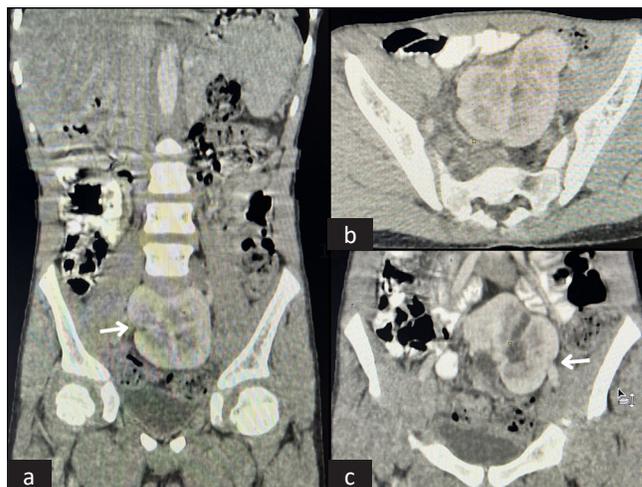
(a-b) Computed Tomography (CT) urography images showing (white arrow in a) the complete medial fusion of the renal parenchyma, located ectopically in the pelvic cavity at the midline. (c) CT urography image (white arrow) showing a single megaureter originating from the left side of the fused renal mass.
